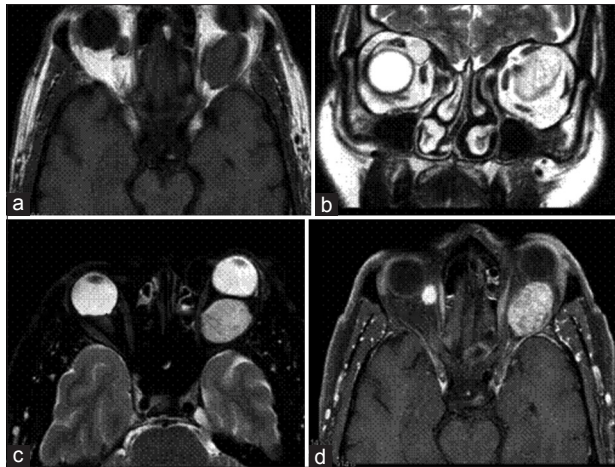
(a) T1-weighted magnetic resonance imaging shows a well-defined mass hypointense in the orbital cavity on both sides. (b and c) T2-weighted shows lesions isointense relative to muscle (d) T1-weighted image after gadolinium injection shows marked uniform enhancement of the masses
